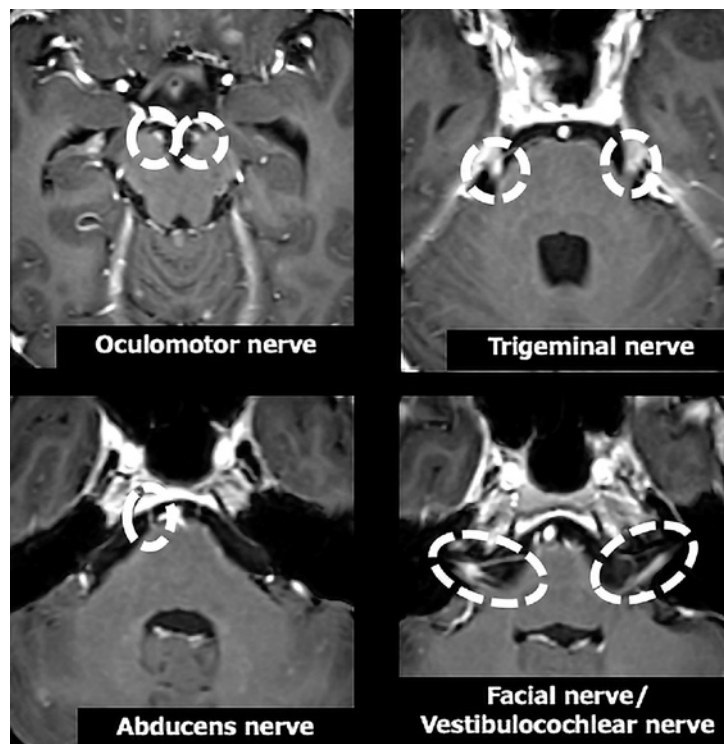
Head contrast-enhanced magnetic resonance imaging findings. The oculomotor, trigeminal, abducens, facial, and vestibulocochlear nerves showed contrast enhancement (dashed circles). The previously treated brain metastases appeared to have shrunk, and no new brain metastases could be observed.
